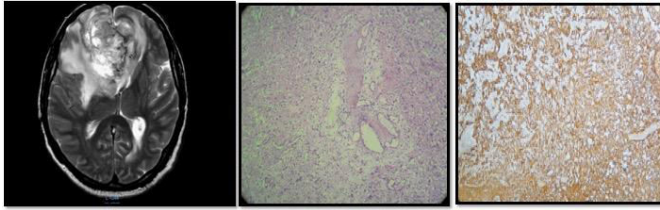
Glioblastoma multiforme A) MRI showing bilateral Fronto-parietal lobe space occupying lesion. B) H& E Section shows pleomorphic astrocytic cells and serpentine necrosis. C) On IHC- tumor cells are positive for GFAP
